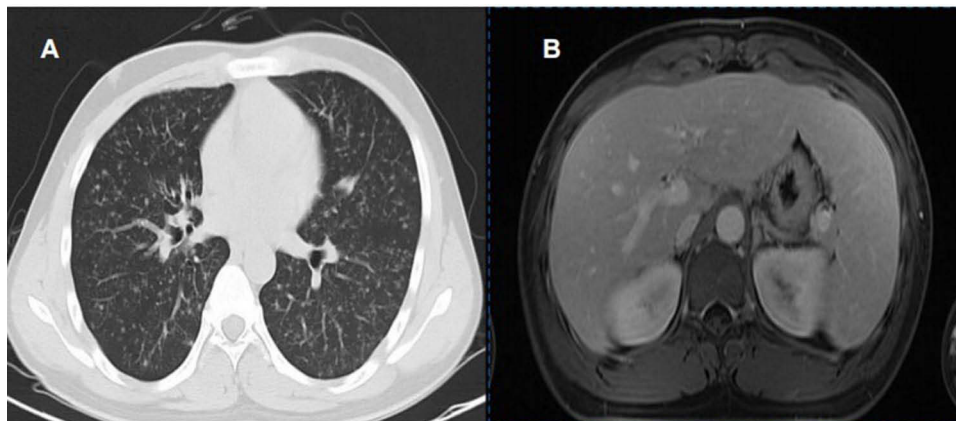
Chest CT and Spleen MRI. (A) Chest CT revealed nodular lesions in both lungs. (B) Upper abdominal MRCP demonstrates splenomegaly with diffuse abnormal signal intensity.
